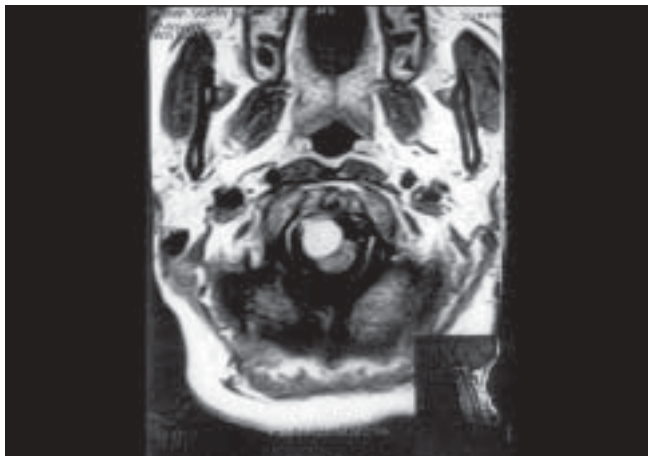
Post-gadolinium DTPA axial section of MRI cervicomedullary junction showing homogenous brilliantly enhancing anterolateral tumor compressing the cord posterolaterally
